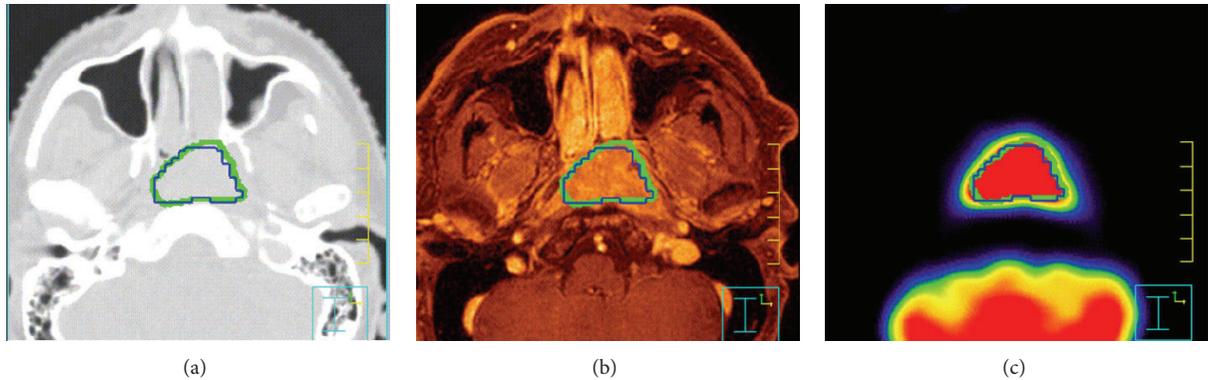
Application of the proposed method to a head and neck tumor: CT (a), MR (b), and PET (c) images (acquired on the biograph Hi-REZ PET scanner). The green ROI corresponds to the GTV delineation manually performed by the radiation oncologist, while the blue one is the result of the application of the 39% TS derived from the thresholding algorithm (TBR = 12, FWHM = 4 mm). The differences between manual GTV and GTV obtained from the thresholding algorithm is 4.3%.
